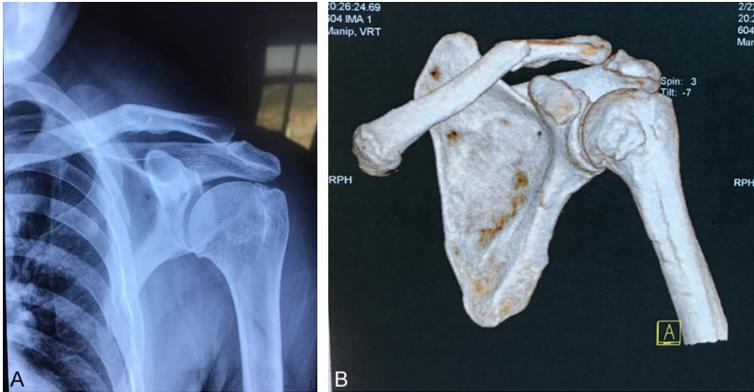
The X-ray and CT scan pictures of the left clavicle (A). The X-ray showed the left clavicle was fractured (B). The CT scan showed the left clavicle was fractured.
